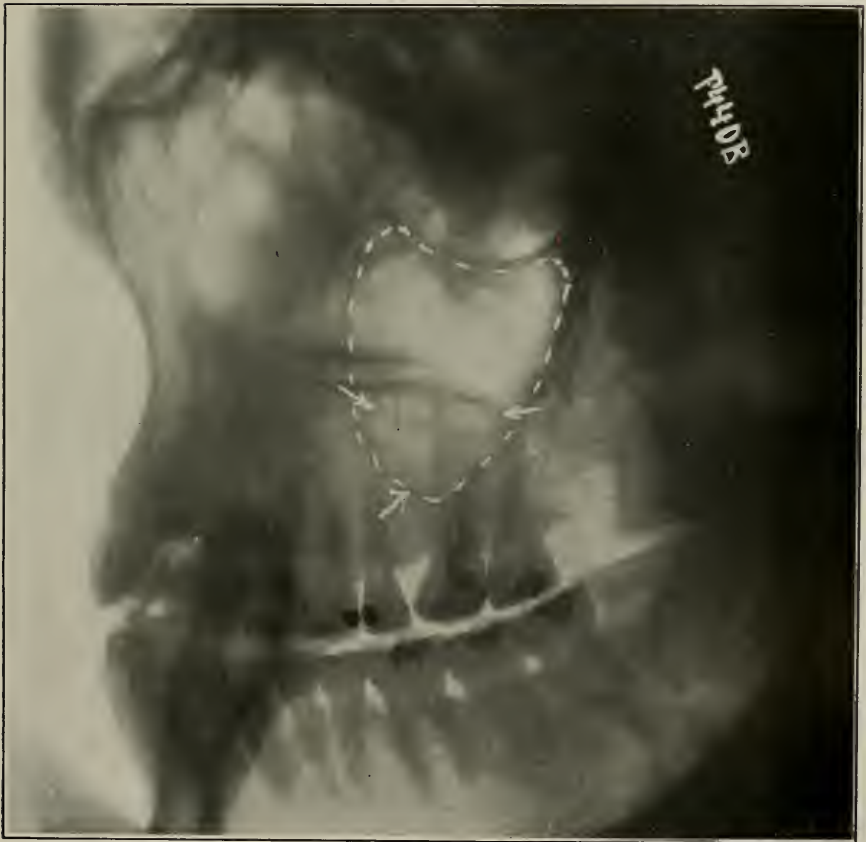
The dots outline a very large antrum. A septum is seen in this antrum dividing it into two parts. The arrows point to the lower part. (Radiograph by Pfahler, of Philadelphia.)
